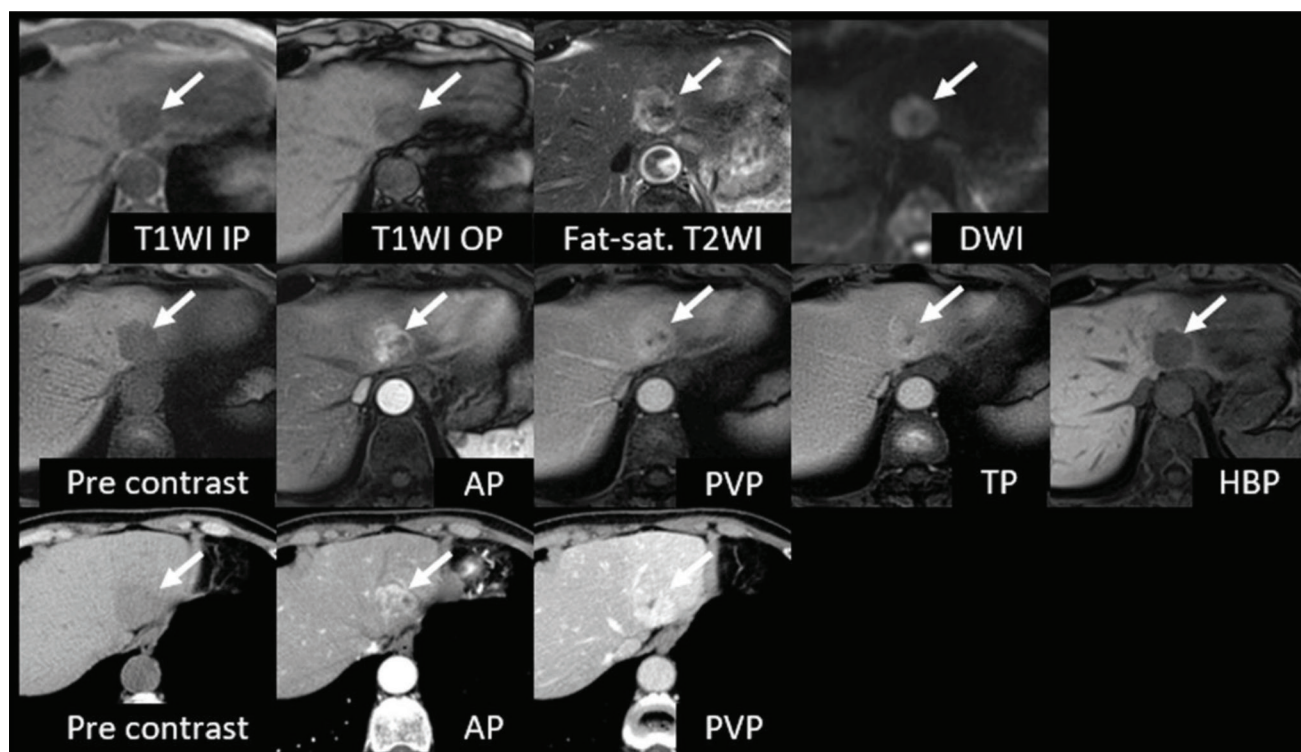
A case of cholangiolocellular carcinoma (CoCC) misdiagnosed as hepatocellular carcinoma (HCC) on magnetic resonance imaging (MRI). The top and middle rows show MR images and the bottom row shows computed tomography (CT) images. A 78-year-old woman had CoCC (24 mm) at S2 (arrows). This lesion did not show marked hyperintensity on T₂-weighted images (T₂WI). Non-rim arterial phase hyperenhancement (APHE) was shown on both CT and MRI. Signal drop of opposed phase (OP) and gadoteric acid uptake at the hepatobiliary phase (HBP) were not observed. Portal venous phase (PVP) and transitional phase (TP) images on MRI showed hyperintensity. This lesion was misdiagnosed as HCC by the logistic model, decision tree of MRI, and radiologist-made practical diagnosis of MRI (both readers scored 5 for both malignancy and HCC). On CT, this lesion was correctly diagnosed as “other lesion” (a category that includes benign and non-HCC malignant lesions) by the decision tree and radiologist-made practical diagnosis (reader 1 scored 2 for malignancy while reader 2 scored 5 for malignancy and 2 for HCC) because non-peripheral washout was not observed. T₁WI, T₁-weighted image; IP, in phase; Fat-sat., fat-saturated; DWI, diffusion-weighted image.
